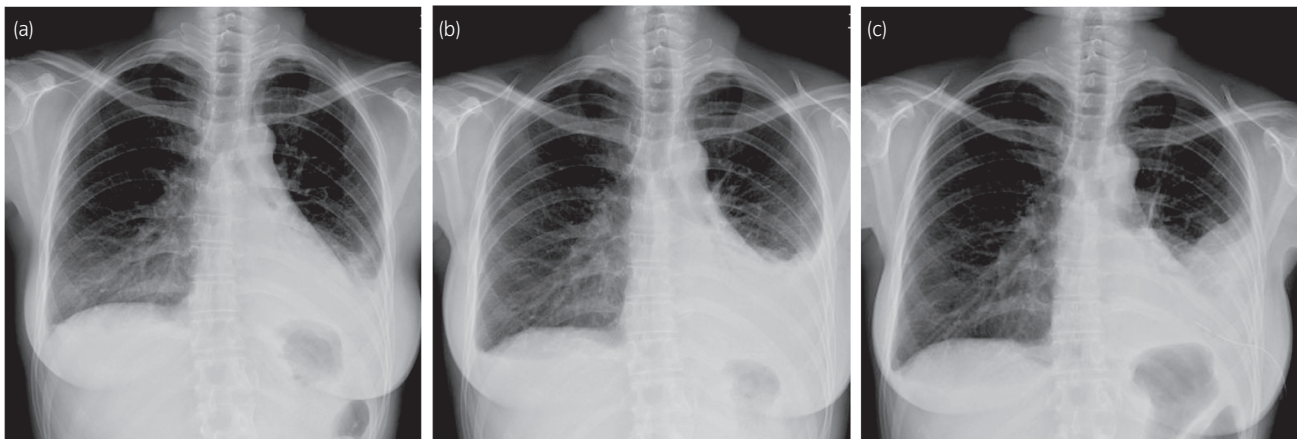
Chest X-ray performed following PCNL showing pleural collection on the left side. (a) On POD 1, pleural collection on the left side was observed. (b) On POD 5, pleural collection was aggravated during conservative management. (c) On POD 9, the left lung did not show expansion after insertion of the drainage tube.
